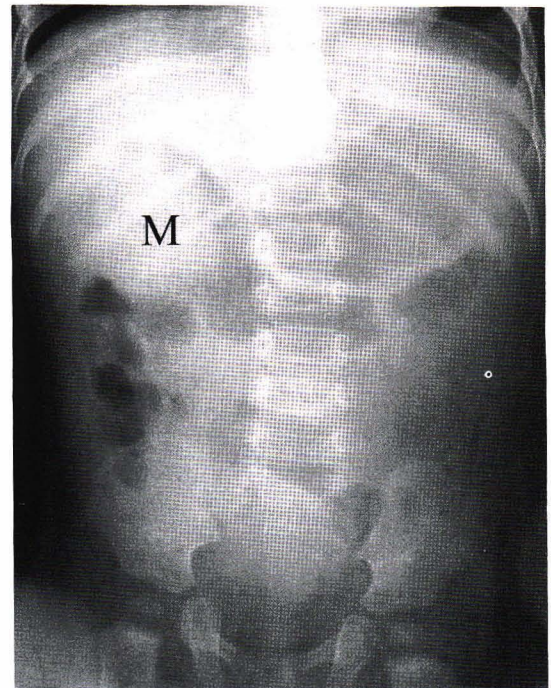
Plain radiograph of abdomen showed soft tissue mass (M) in right upper quadrant with colonic gas outlining medially, the so-call meniscus sign which is characteristic for the ileocolic intussusception.
